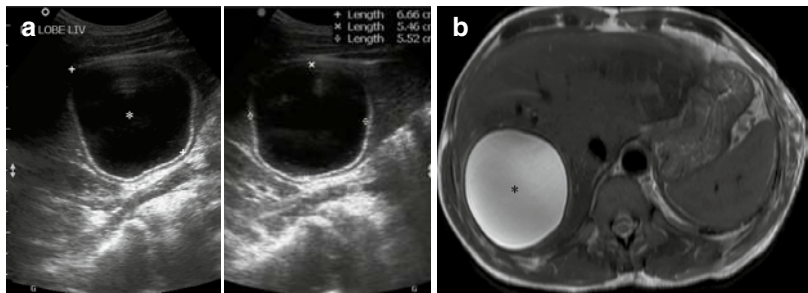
Hydatid cyst liver, WHO grade CE 1. Unilocular hepatic hydatid cyst seen as a well-defined anechoic lesion with posterior acoustic enhancement on ultrasound (white asterisk in a) and a homogeneously T2w hyperintense lesion with a hypointense rim on MRI (black asterisk in b)
